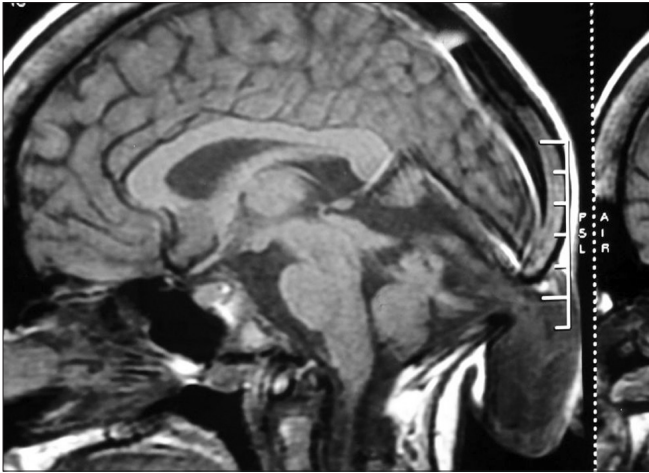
Sagittal MRI shows torcular encephalocele containing brain tissue
